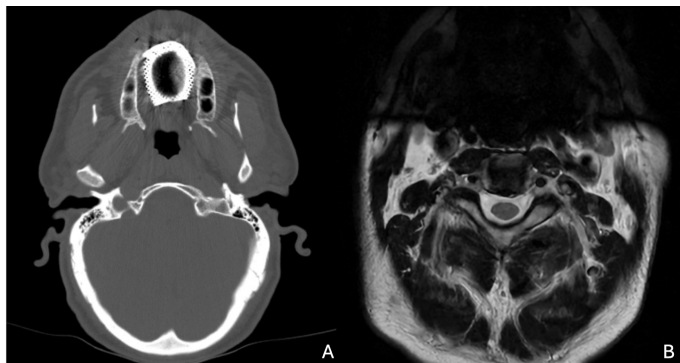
Computed tomography (a) and MRI (b) axial sections showing significant signal loss in the anterior region due to the removable prosthetics in the maxilla.
